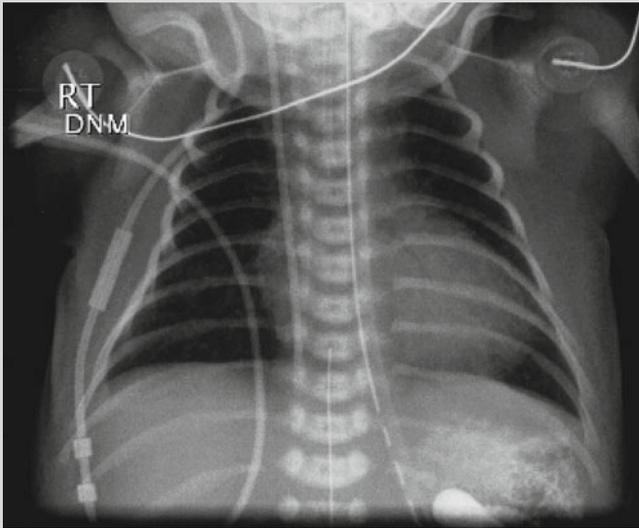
Initial chest radiograph showing bilateral alveolar filling and mild cardiomegaly
